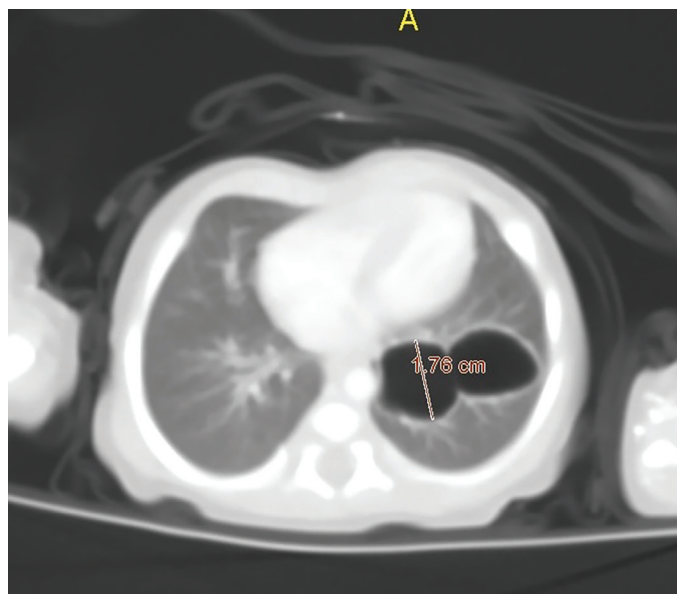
Axial CT scan of chest demonstrates a left lower lobe lesion with two cysts
